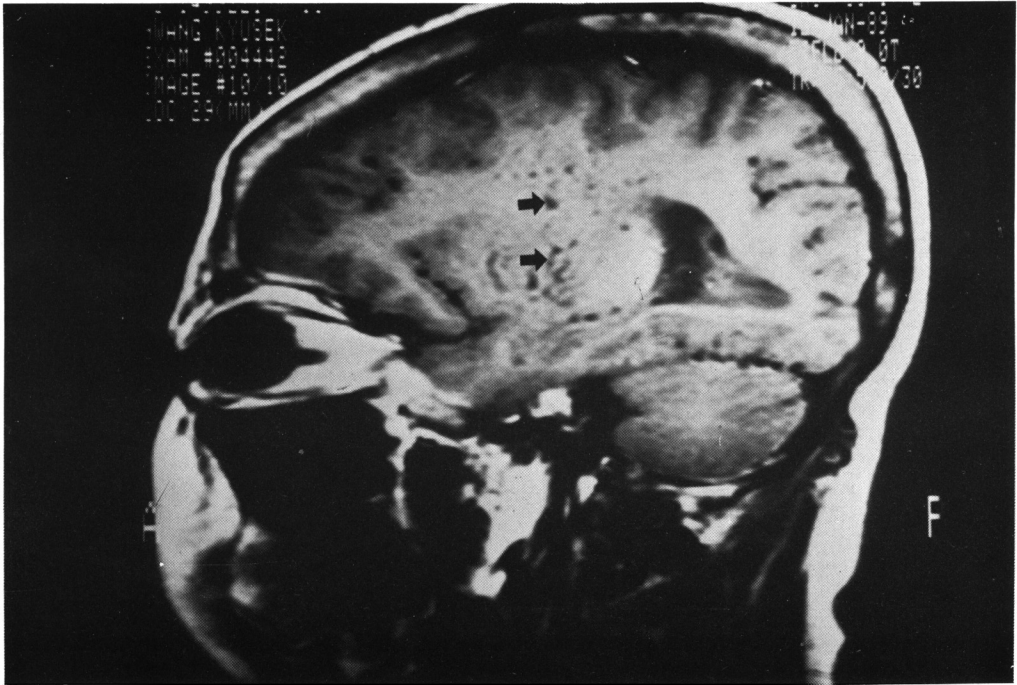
T1-weighted sagittal MR image (SE 500/30) of collateral vessels. Multiple, small, round or tortuous signal void collateral vessels (arrows) are well seen in the basal ganglia and periventricular white matter.
